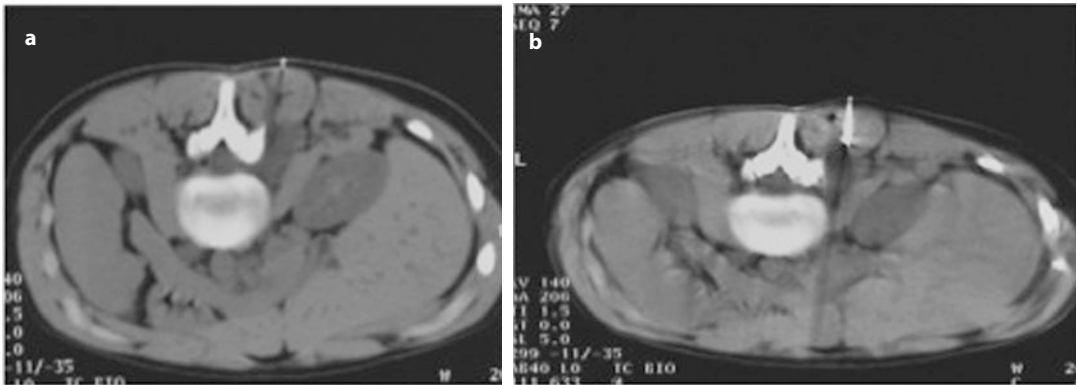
CT-guided approach to identify a flogistic collection in a case of spondylodiscitis. Different position of the needle: on skin surface (a) and within the collection (b)
